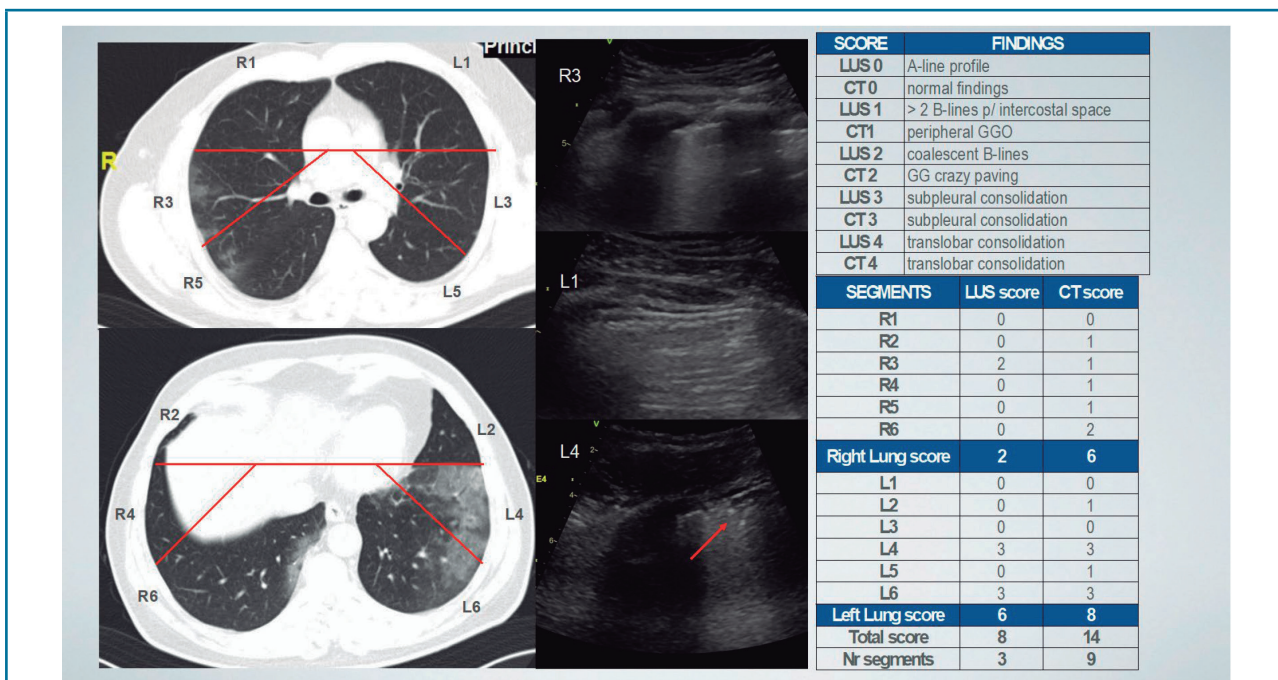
Example of 61 year old male patient showing CT segmentation and corresponding LUS showing subpleural in a patient with predominant peripheral ground glass opacification (GGO) and subpleural consolidation restricted to L4 and L6 as demonstrated by both methods. Left panel: CT segmentation and findings; middle panel: LUS findings in 3 segments and right panel: scoring according to findings and structured scoring table, right lung (R) and left lung (L).
